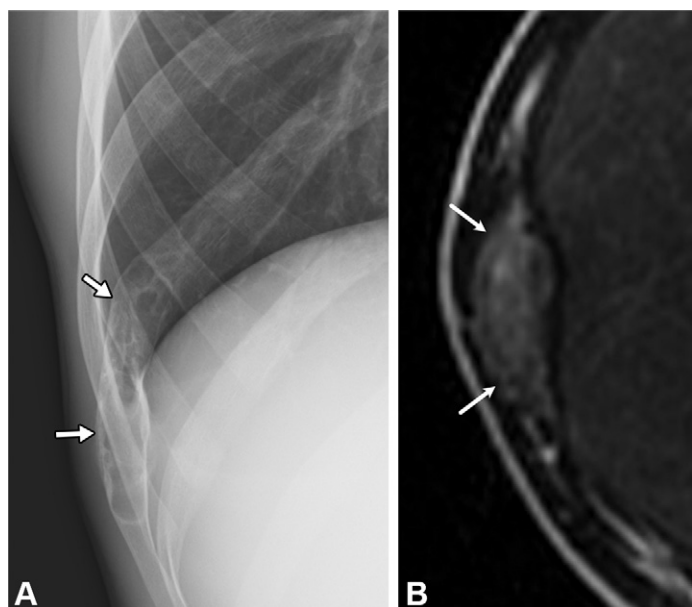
Fibrous dysplasia in a 16-year-old adolescent boy. (A) Frontal chest radiograph shows an elongated lucent lesion (arrows) intervened by ground-glass opacities in the posterolateral aspect of the right ninth rib. (B) Axial T2-weighted MR image shows a well-defined lesion (arrows) with heterogeneous signal intensity composed of intermediate signal intensity mixed with areas of hypointensity and smaller areas of hyperintensity.
